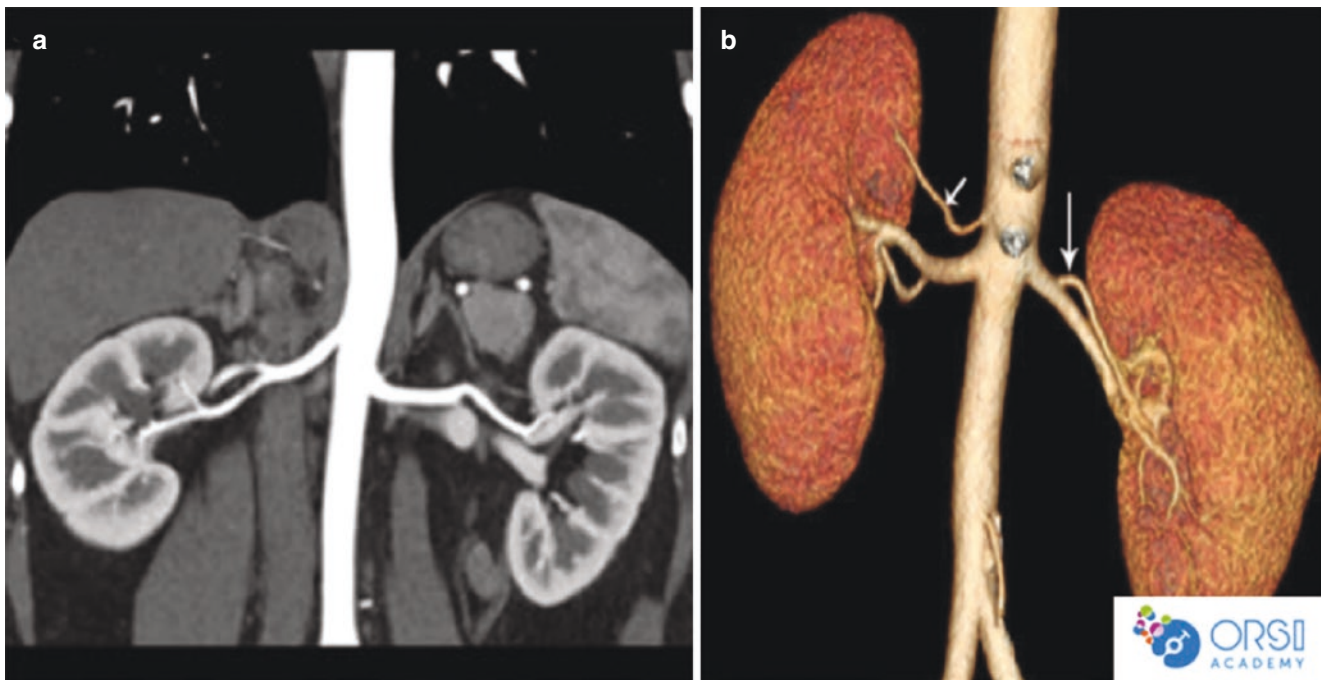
(a) CT renal angiogram in a coronal view showing the bifurcation of the main renal arteries; (b) CT 3D reconstruction image exposing a right upper pole renal artery
